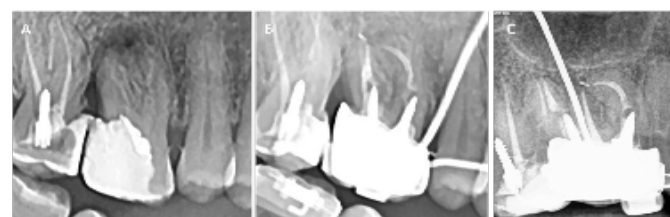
Radiographs of root canal treatment performed with RealSeal SE at level 1.6. A-baseline B-6 months C-12 months
